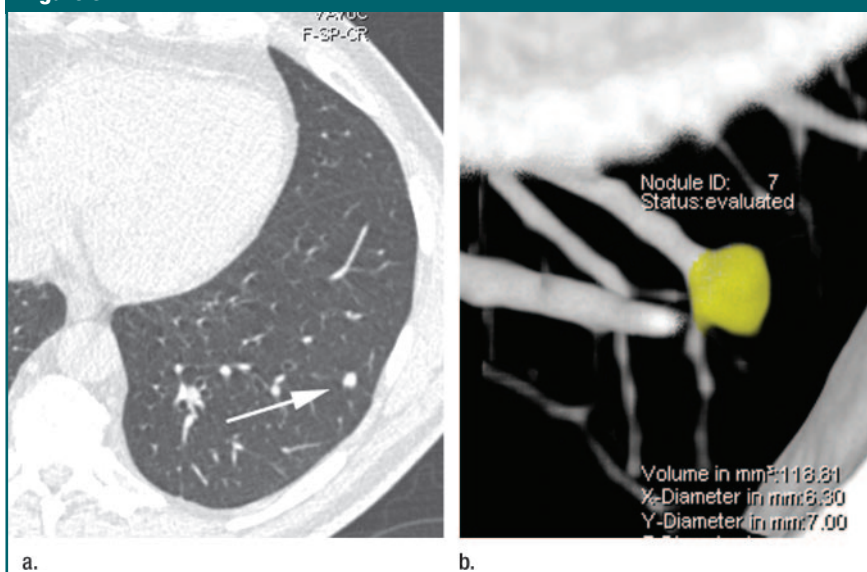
(a) Transverse thin-section CT and (b) volume-rendered reconstruction images show solid juxtavascular pulmonary nodule (arrow in a and yellow area in b) detected at baseline screening in the NELSON study.
